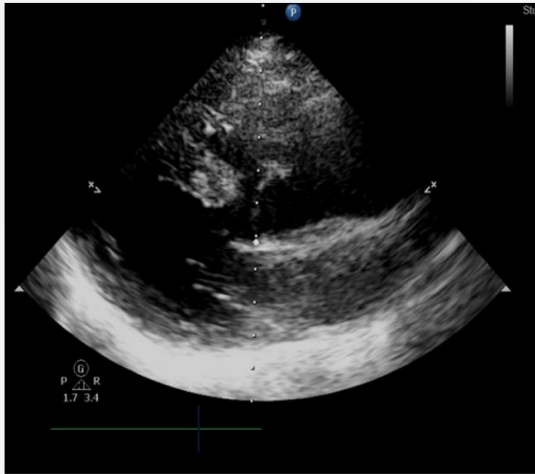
22 year male with unrepaired TOF with Pulmonary Atresia; showing dilated aortic root (echo & CT)
